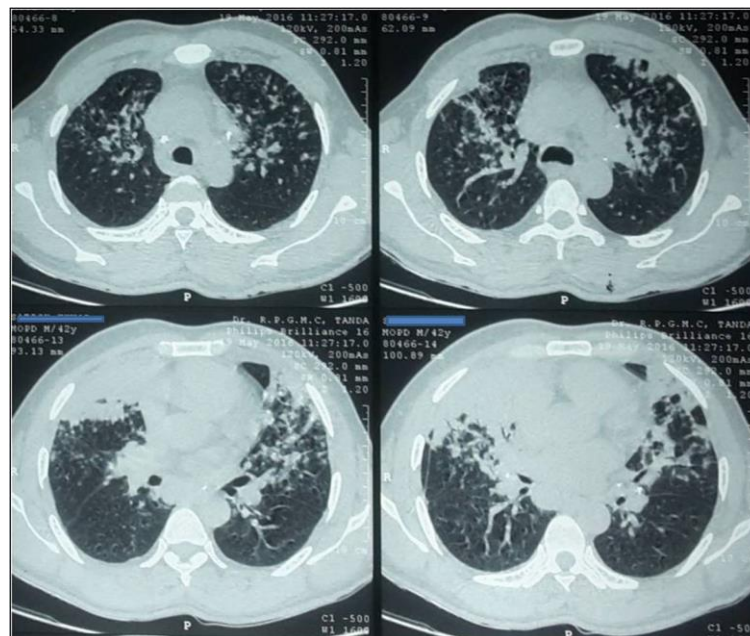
Axial CT (lung window) showing multiple ill-defined nodular densities, ground glass opacities with patchy areas of consolidation and tree in bud pattern
